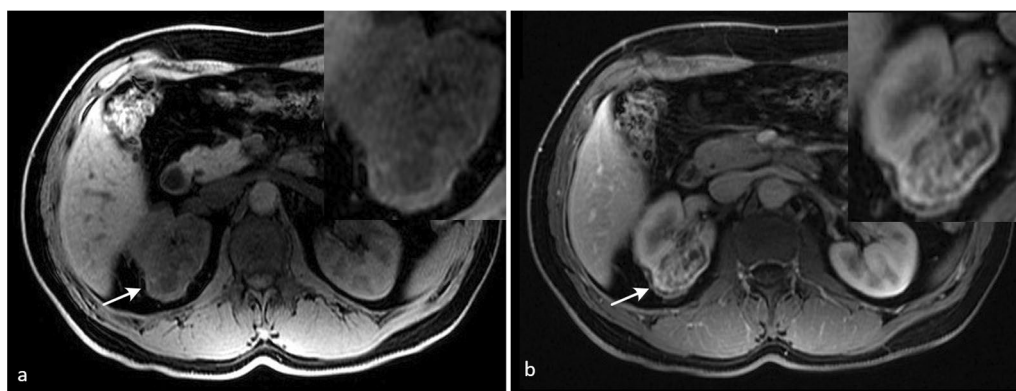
Follow-up MRI at 3 months. a T1WI sequence showing regions of hyperintensity in the cystic space (proteinaceous material). b Contrast-enhanced axial T1-weighted sequence, in arterial phase, showing cyst's thickened wall (arrow)
